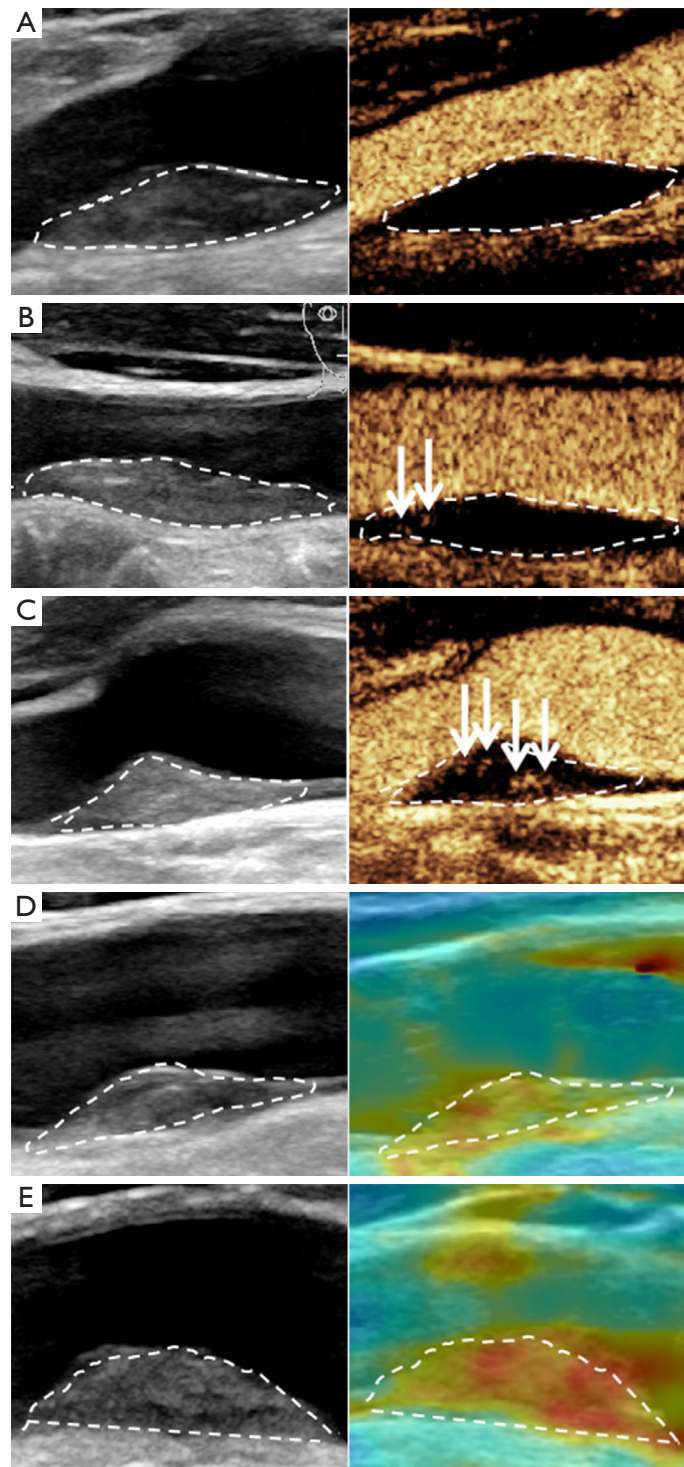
CEUS and SWE images of IPN grades and plaque elasticity. (A) Grade 0 IPN, (B) grade 1 IPN, (C) grade 2 IPN, (D) soft plaque, and (E) hard plaque. The white dotted lines represent the plaque margins. The white arrows represent intraplaque neovascularization. CEUS, contrast-enhanced ultrasound; SWE, shear wave elastography; IPN, intraplaque neovascularization.
